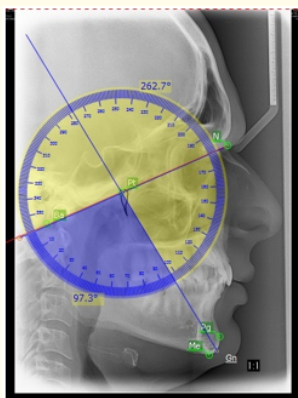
Digital lateral cephalometric radiograph showing patient with class II skeletal pattern and hypodivergent vertical facial pattern.
